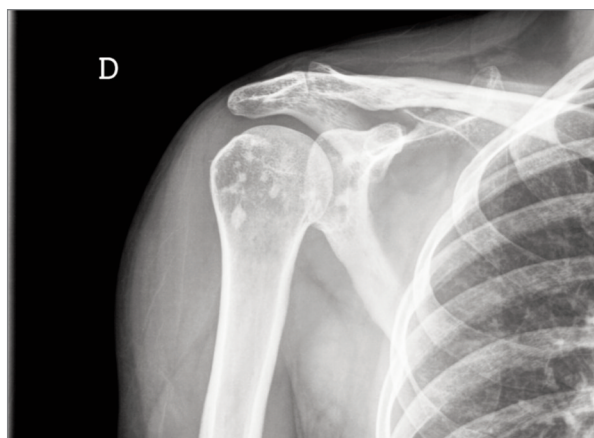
Right shoulder AP radiography (case 5)
